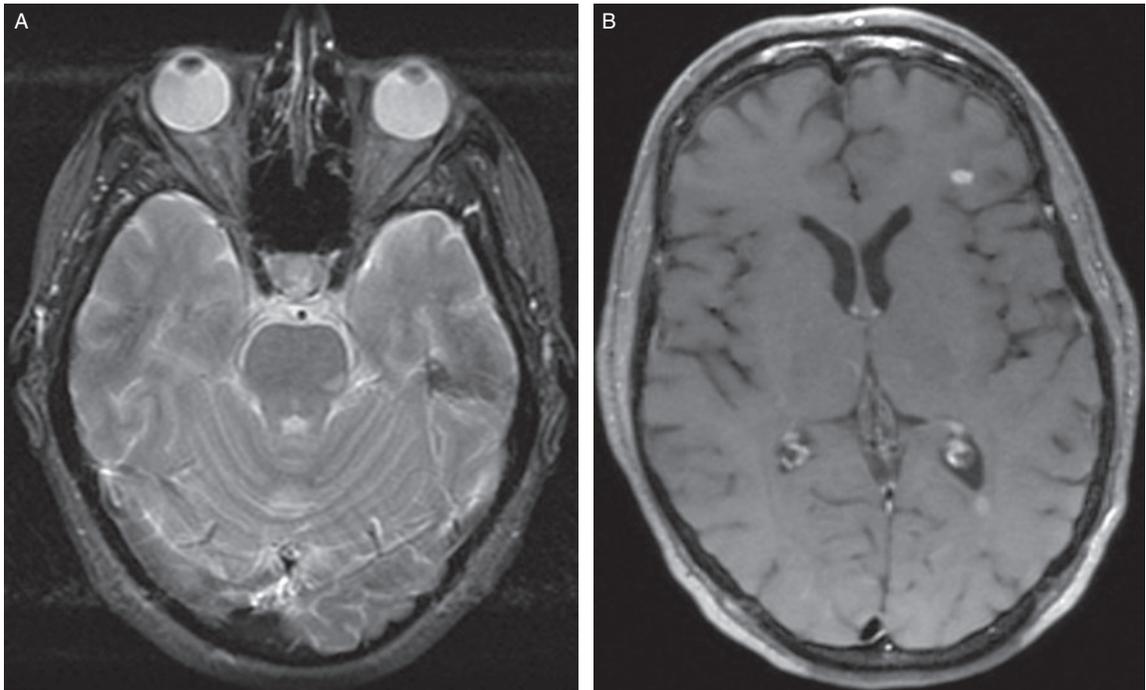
A) Axial T2 MRI brain showing left pontine MS lesion. B) Axial T1 MRI brain with gadolinium showing enhancing white matter lesion in left frontal lobe.
